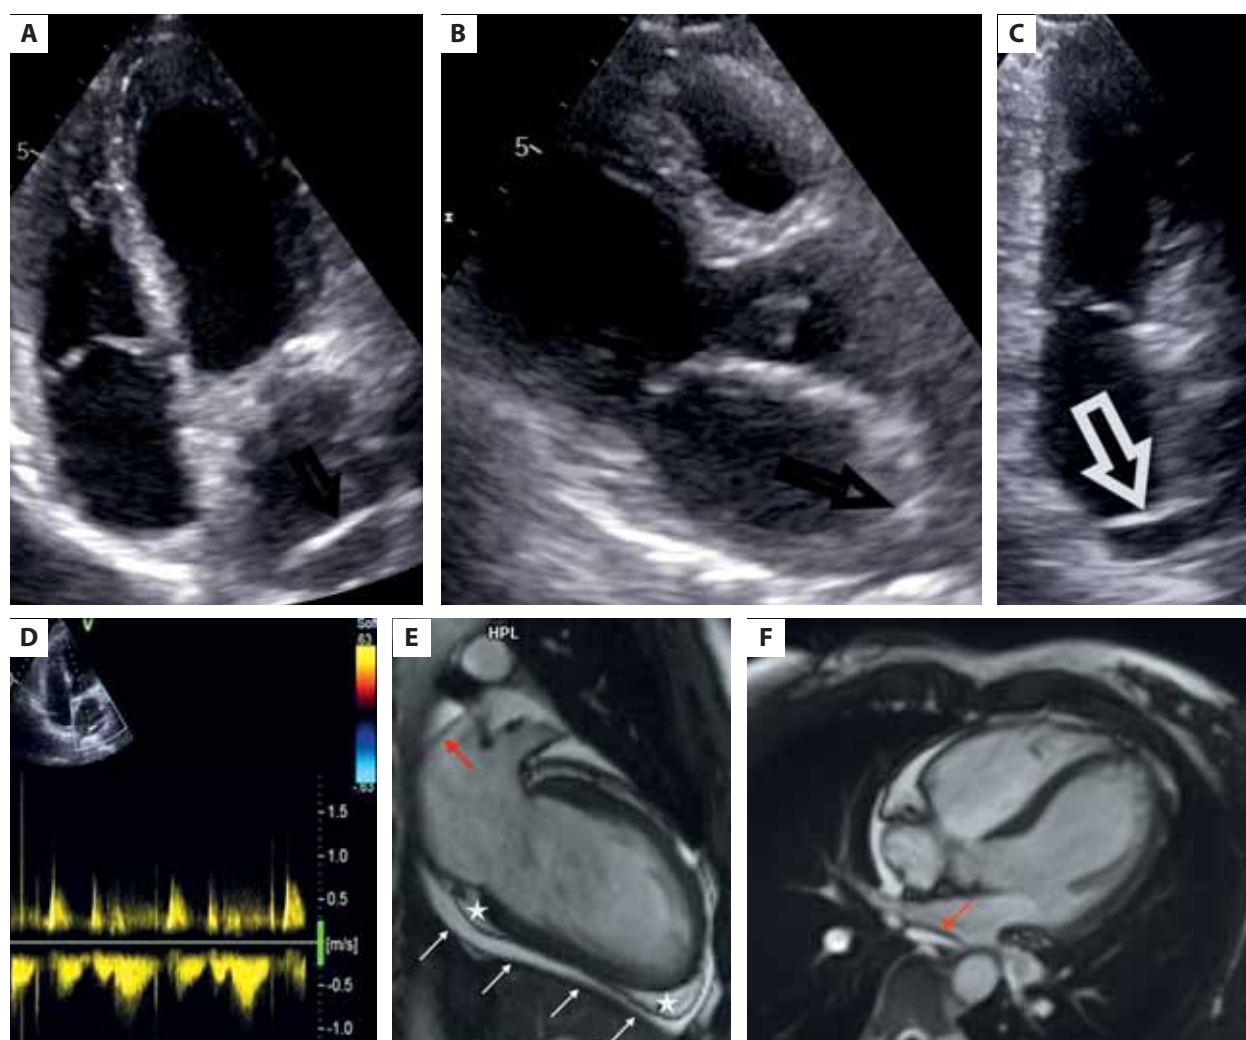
A–D. Transthoracic echocardiography. A–C. Additional membranous structure in the left atrium (arrows); four-chamber view (A), parasternal long axis view (B), two-chamber view (C). D. No significant gradient across the membrane on continuous wave Doppler; four-chamber view. E, F. Cardiac magnetic resonance imaging performed a few months later showing pericardial effusion mainly in the oblique sinus of the pericardium (red arrows); fluid along the inferior wall (white arrows); epicardial fat (asterisks)
